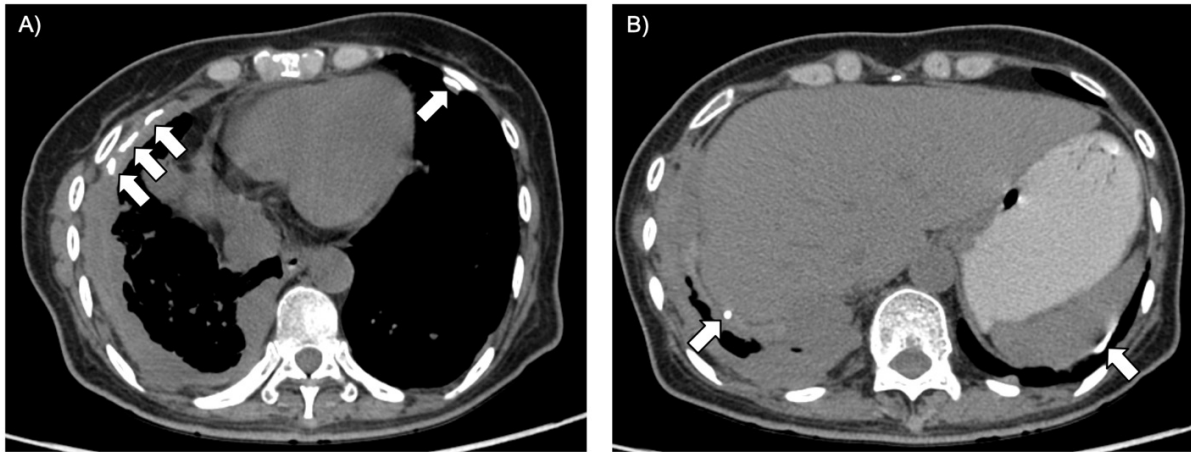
Axial non-contrast chest CT images (mediastinal-window setting) showing calcified pleural plaques (arrows) at the anterolateral aspect of the bilateral chest walls (A) and along both hemidiaphragms (B).
